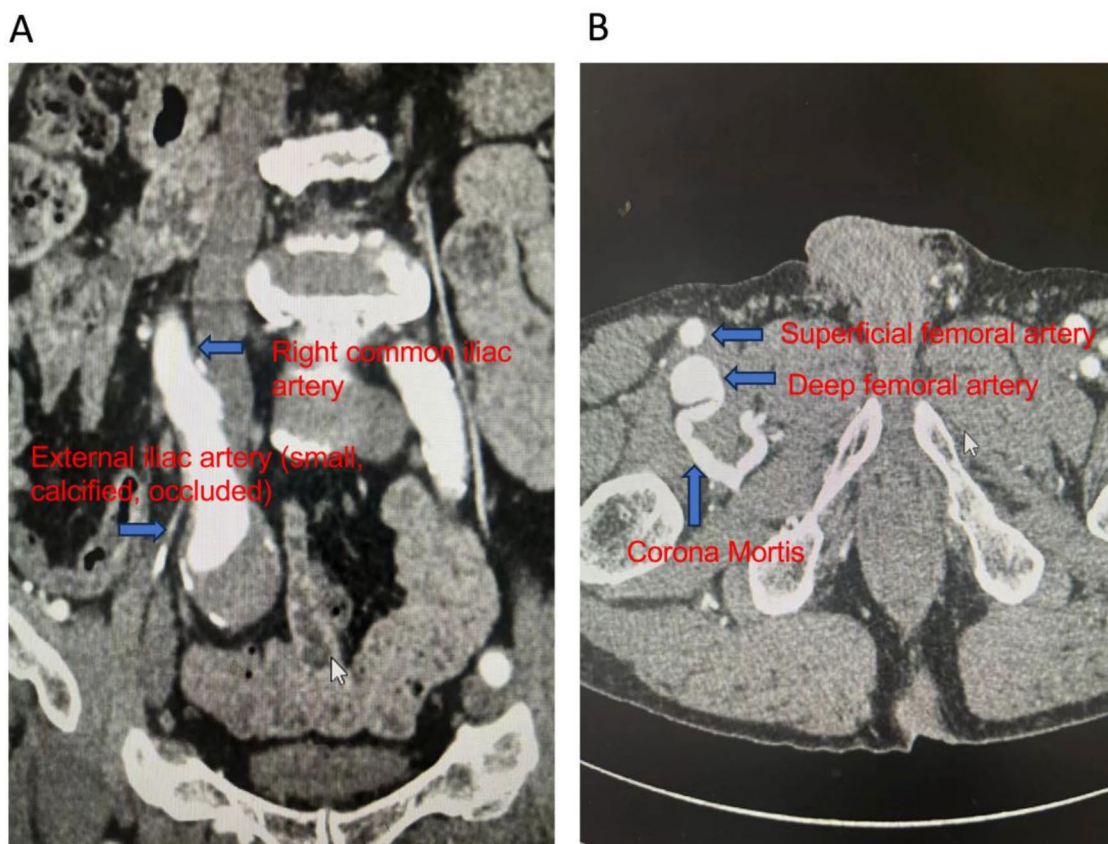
A. Preoperative CTA showed that the right EIA was slender, calcified and occluded. B. Collateral circulation involving the enlarged profunda femoris artery is also depicted
